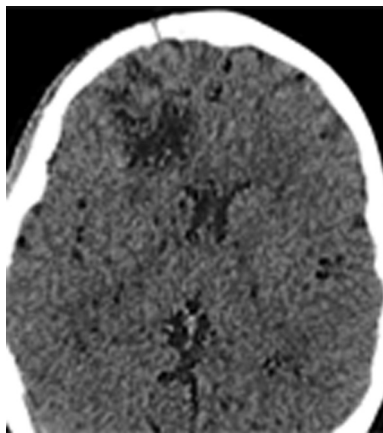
Brain computed tomography: posthemorrhagic cyst in the right frontal lobe.
